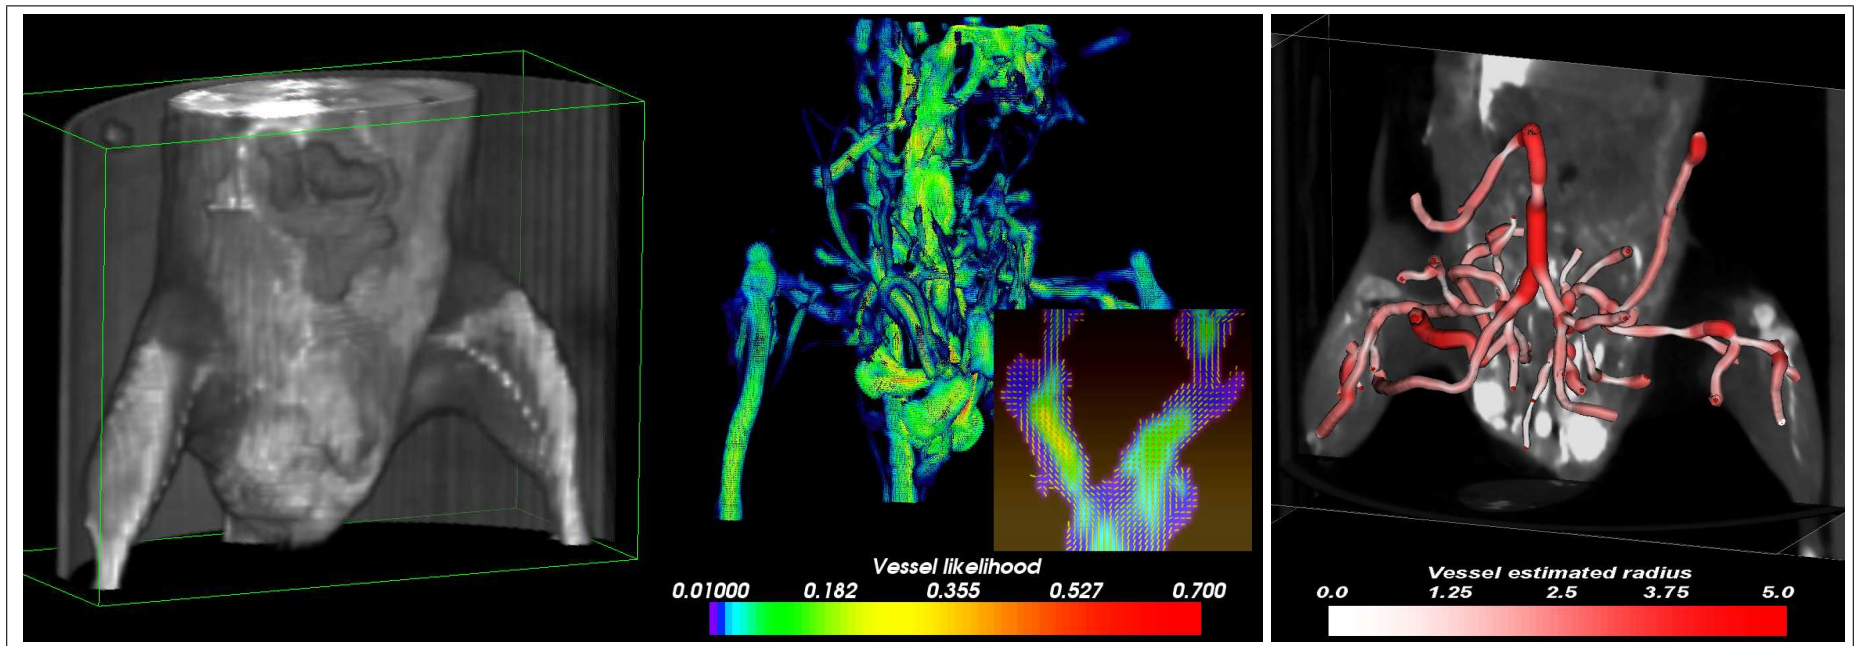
Angiography (Top) Volume rendering of original CT angiographic data. (Middle) 3D view of the extracted vector field indicating the presence and orientation of possible vessels. (Right) Reconstruction of the major vessels connecting to the aorta, colored according to their estimated size.
